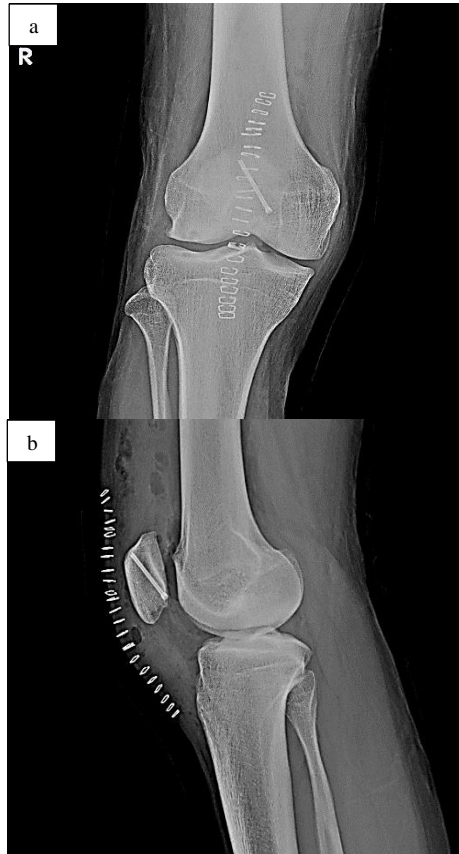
Post-operative radiographs of osteochondral fracture fixed with headless compression screw (a and b)
